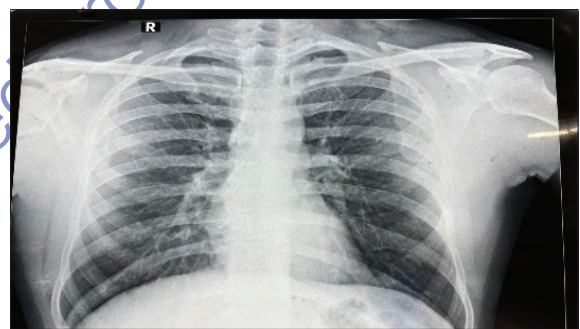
(a) Panoramic. (b) Plain chest Xray chest.
